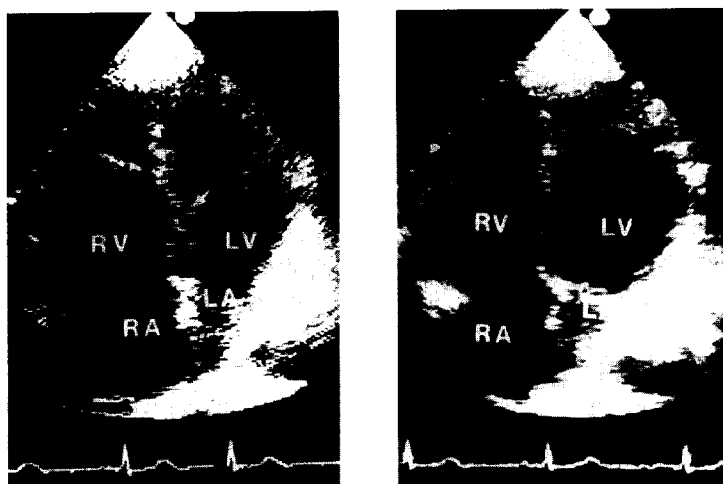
Echocardiograms (four-chamber view) in a 53-year-old previously healthy man with a high-probability lung scan for pulmonary embolism. *Left*, Right ventricular enlargement before treatment. The right ventricular end-diastolic area was 42.9 cm², and the interventricular septum (arrow) was displaced toward the left ventricle. *Right*, 3 hours after initiating rt-PA therapy, the right ventricle normalized in size (with a planimetered area of 25.7 cm²), and the interventricular septum resumed its normal configuration.
